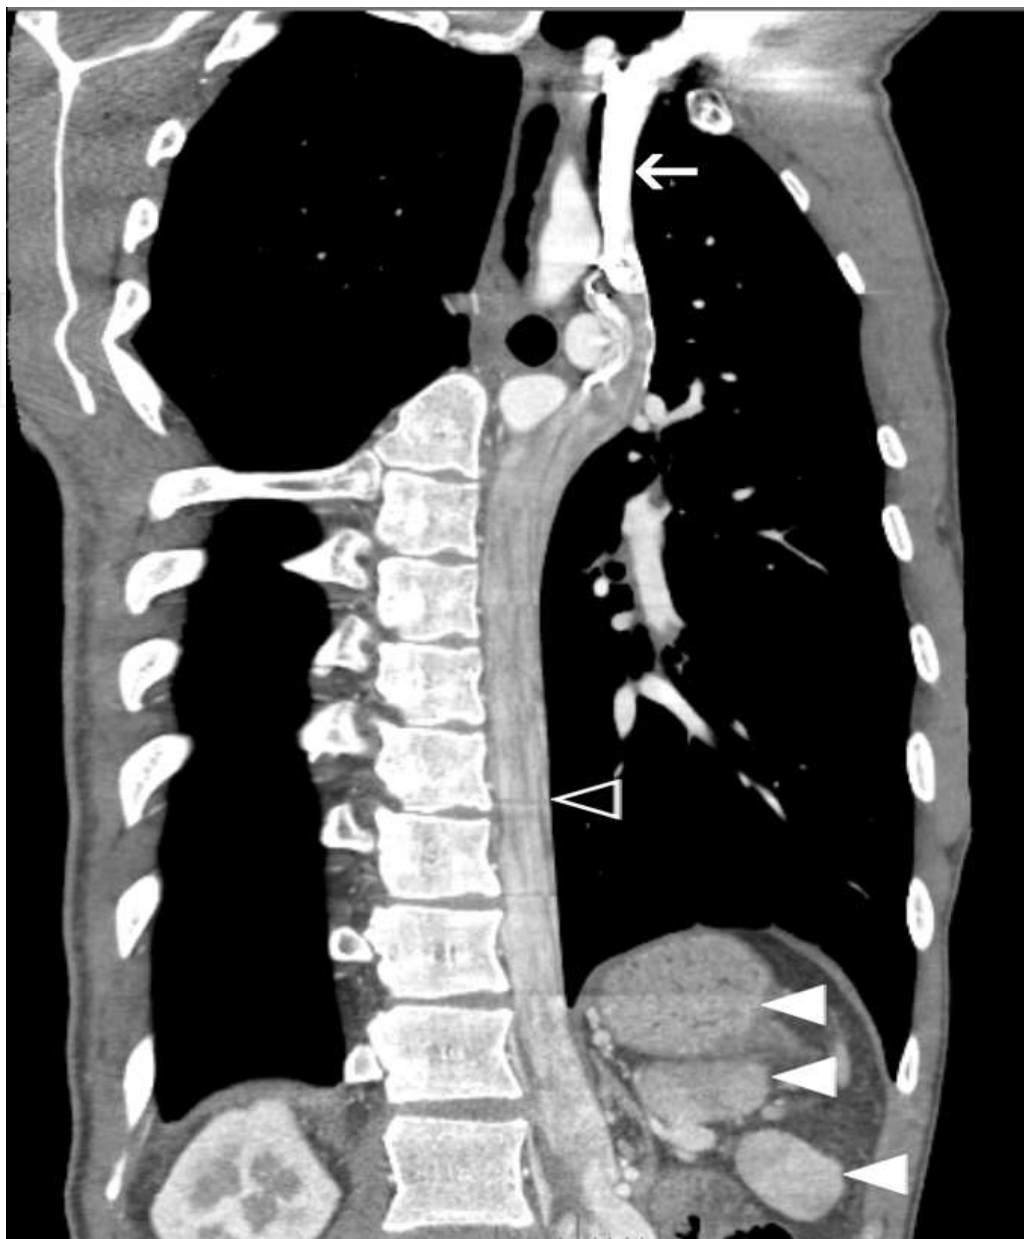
Multiplanar curved line reformation of thoracic CT examination in a patient with heterotaxy-polysplenia syndrome. Arrow - PLSVC, blank arrowhead - hemiazygos vein, arrowheads - multiple spleens.
